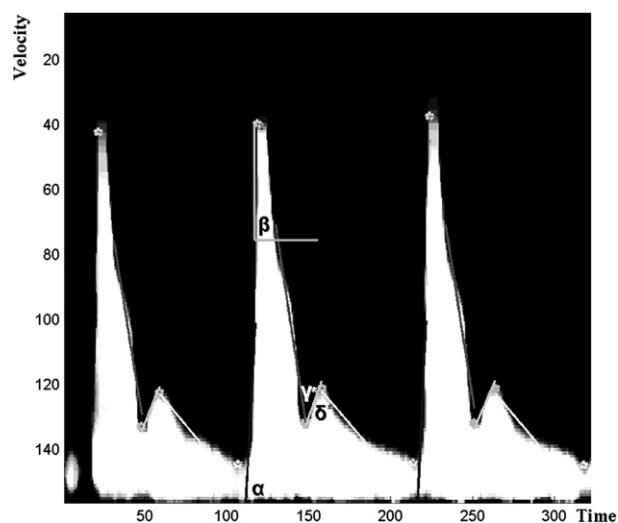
Doppler waveform: angles of measurement are presented:  $\alpha$  angle: the angle of the wave between the time axis X and the linear fit.  $\beta$  angle: the angle of the wave between the time axis X and the straight line that connects 2 points on the curve.  $\gamma$  and  $\delta$ : angles of refraction.
